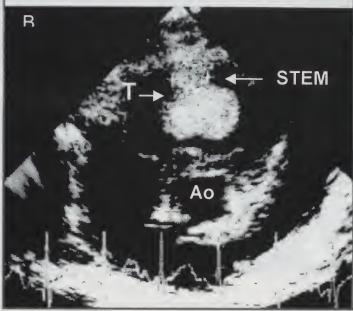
Two-dimensiotal echocardiogram of patient at age 1 month, Parasternal short-axis in: (A) Diastole and (B) Systole. In diastole the free-floating intracavitary right ventricular tumor moves towards the scanning plane so that it appears to occupy the entire right ventricular outflow tract. In systole the tumor moves away from the scanning plane so that its attachment to the right ventricular free wall is revealed. T, Tumor; Ao, Aorta; PA, Pulmonary Artery.
